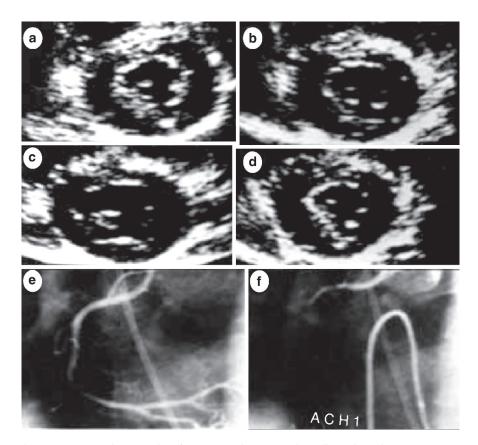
Representative examples of a–d ergonovine stress echocardiography and e, f coronary angiography in a 53-year-old man with early-morning chest pain. Treadmill test results were negative up to stage 4 of the Bruce protocol, and ergonovine echocardiography was done. Left ventricular wall motion at end-systole recorded in the parasternal short-axis view was demonstrated in quad screen format. a Basal status. b Left ventricular wall motion after injection of 0.05 mg ergonovine. c Regional loss of systolic myocardial thickening in the mid-inferior segment with an ergonovine dose of 0.1 mg and d recovery of regional wall motion abnormality with nitroglycerin, a finding suggestive of myocardial ischemia in the region of the right coronary artery due to coronary vasospasm. e Coronary angiogram taken 2 days later revealed a normal right coronary artery. f Intracoronary injection of acetylcholine (ACH) provoked total occlusion of the proximal right coronary artery, which was compatible with coronary vasospasm. (From [9], with permission)
